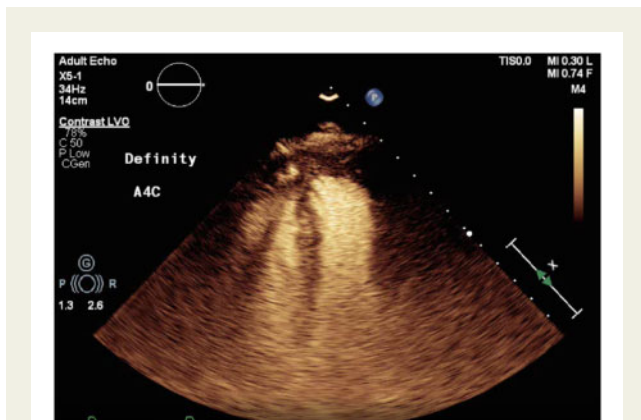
Transthoracic echocardiogram: a protruding density in the basal-mid interventricular septum can be seen, measuring  $2.2 \times 1.4$  cm at the site of the remote myectomy.
